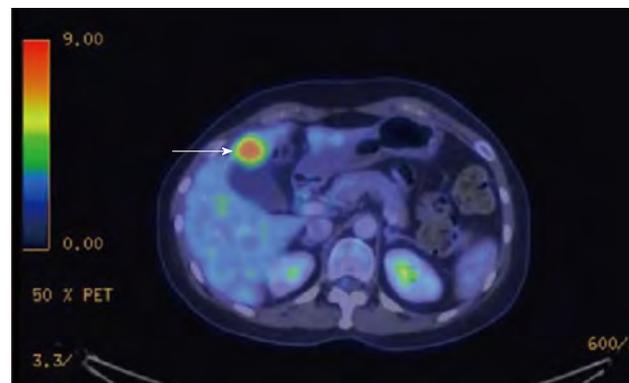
Computed tomography-positron emission tomography scan revealing the positron emission tomography avid lesion in segment IVb of the liver. Cross-sectional image of the positron emission tomography avid lesion in segment IVb of the liver (standardized uptake value 7.9) (arrow).
